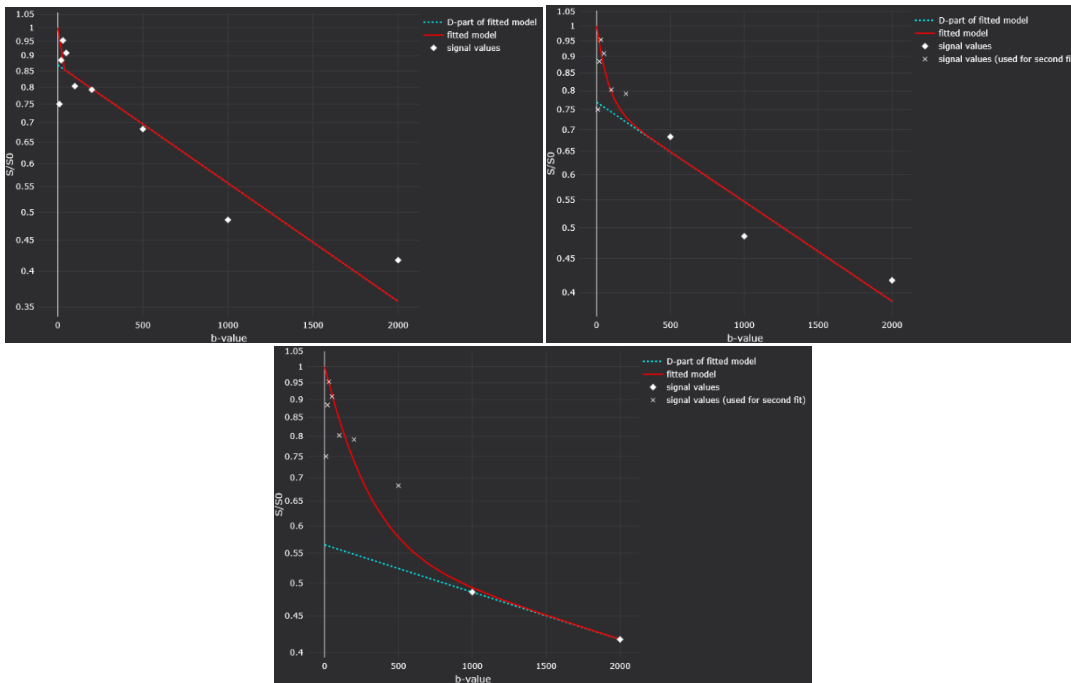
The fitting IVIM curves acquired with the fitting algorithm “Fit D and f (with high b), then fit D*” with three different values of the parameter “ignore b < (first fit),” the input is the 4D DWI image of 10 b values, implemented in the MITK tool. x-axis: b values, y-axis: the signal attenuation in the range between 0 and 1. The left image on the top: ignore b < (first fit) = 0, the right image on the top: ignore b < (first fit) = 300, the image at the bottom: ignore b < (first fit) = 600. Red curve: the total IVIM fitting curve, the green dashed curve: the fitting curve with b values above the threshold. If the b-value threshold is set to a low value (e.g. $b = 0 \left[\frac{s}{mm^2} \right]$) both curves are overlapped and the IVIM effect at low b values is not enhanced, the D* value calculation is underestimated. Conversely, if the b value threshold is set to a high value (e.g. $b = 600 \left[\frac{s}{mm^2} \right]$) both curves are highly separated, and the D* value calculation is overestimated. The optimal threshold b value is approximately $b = 300 \left[\frac{s}{mm^2} \right]$ in which both curves are separated at low b values.
